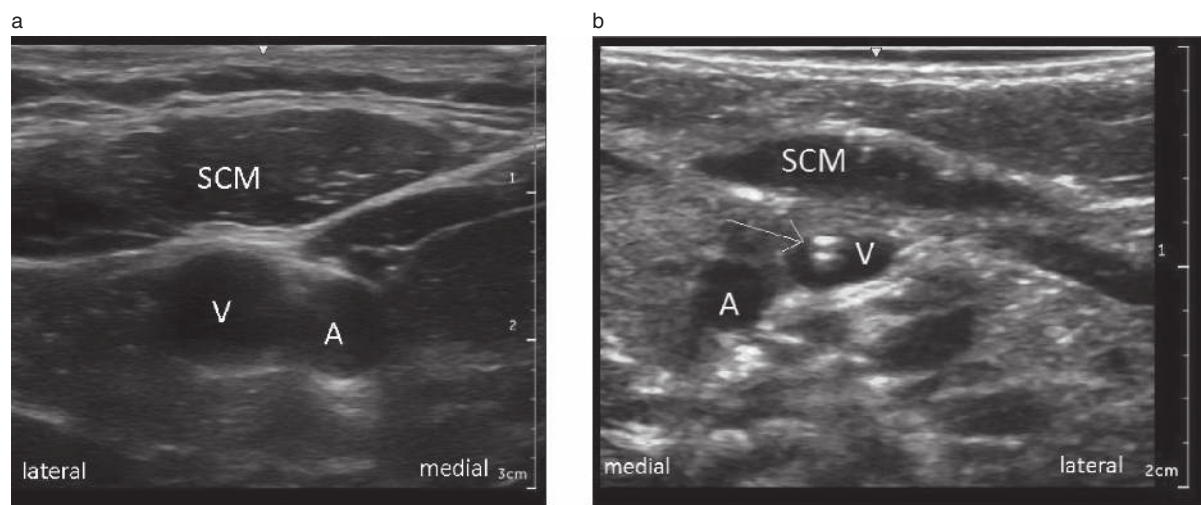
Ultrasound pictures of the internal jugular vessels. Figure 1.1a. shows the left neck vessels in a 3-year-old. Figure 1.1b. shows the right neck vessels in a newborn. A = carotid artery, V = internal jugular vein, SCM = sternocleidomastoid muscle. The arrow is pointing to the central line within the IJ lumen after cannulation. IJ = internal jugular.
